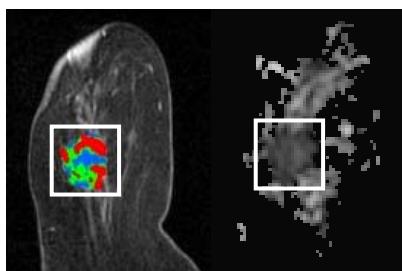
A 2.2cm invasive ductal carcinoma in an 85-year-old woman, which showed significant washout (red) on DCE and low ADC on DWI.
